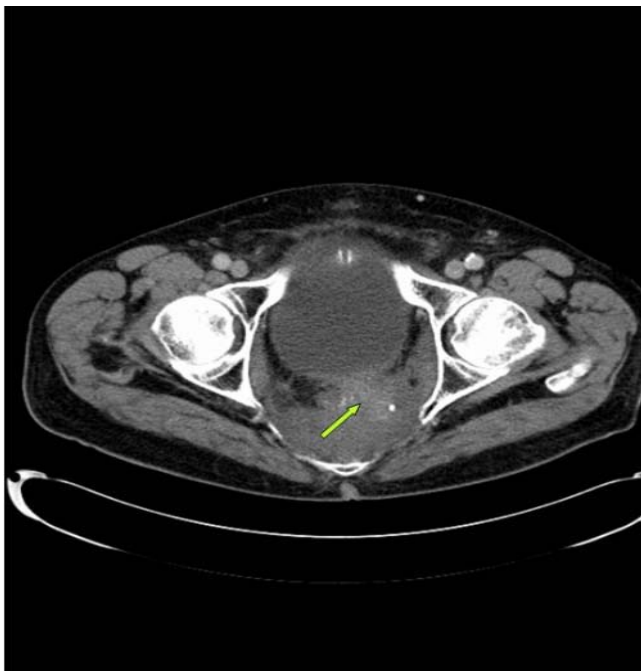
CT scan of the pelvis showing local recurrence: a soft tissue mass in the pre-sacral space (arrow) is inseparable from thickened posterior bladder wall and the left pelvic side wall muscles.
